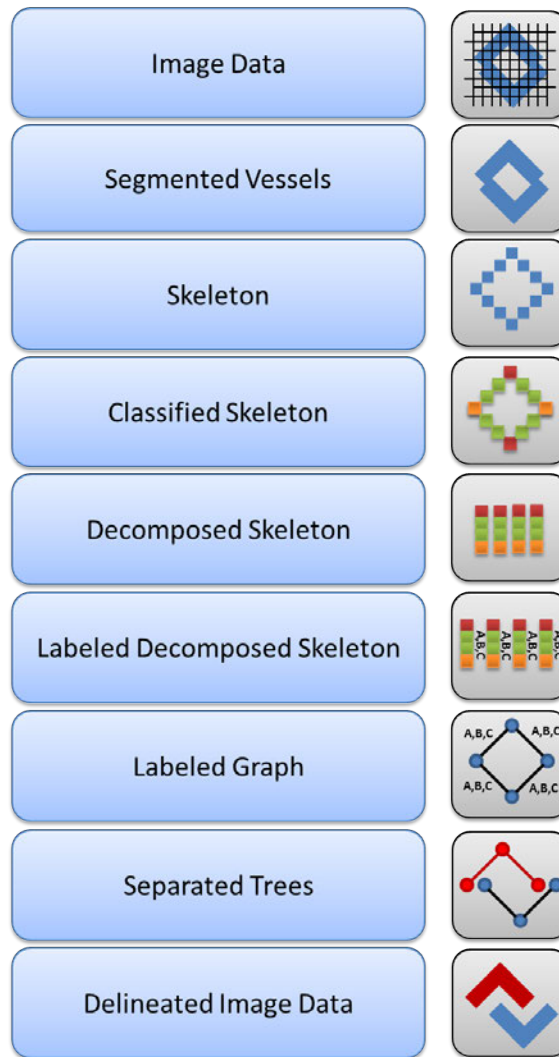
Layer model consisting of several steps to extract hepatic veins from contrast enhanced CT data. The pictograms on the right side visualize the outcome of each layer. Image taken from [DOL10c].
